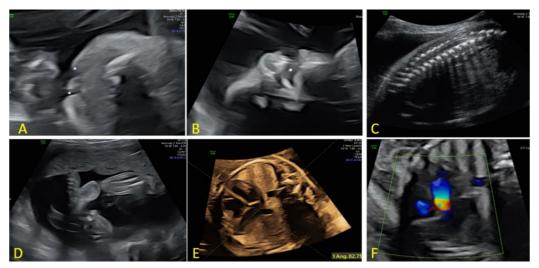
Ultrasound images of the fetus demonstrating the bilateral cleft lip (A and B) and clubfoot(D) . Left axis deviation of the heart (E) with inlet VSD (F) was noted . No evidence of tethered cord or spinal deformity was noted (C)
